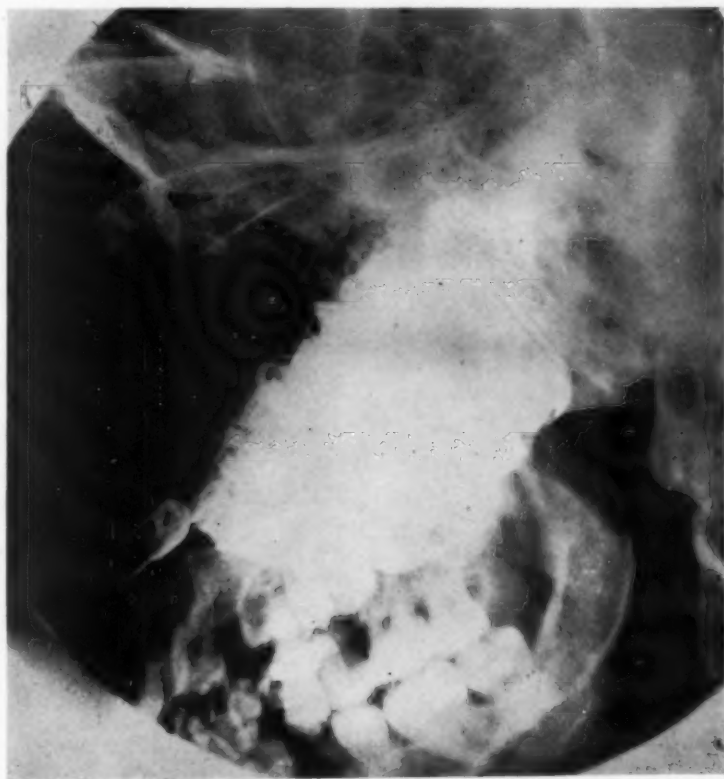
Case 12. Radiograph, postoperative, of neurofibroma, showing the extent of the tumor. (Neg. 77435.)
